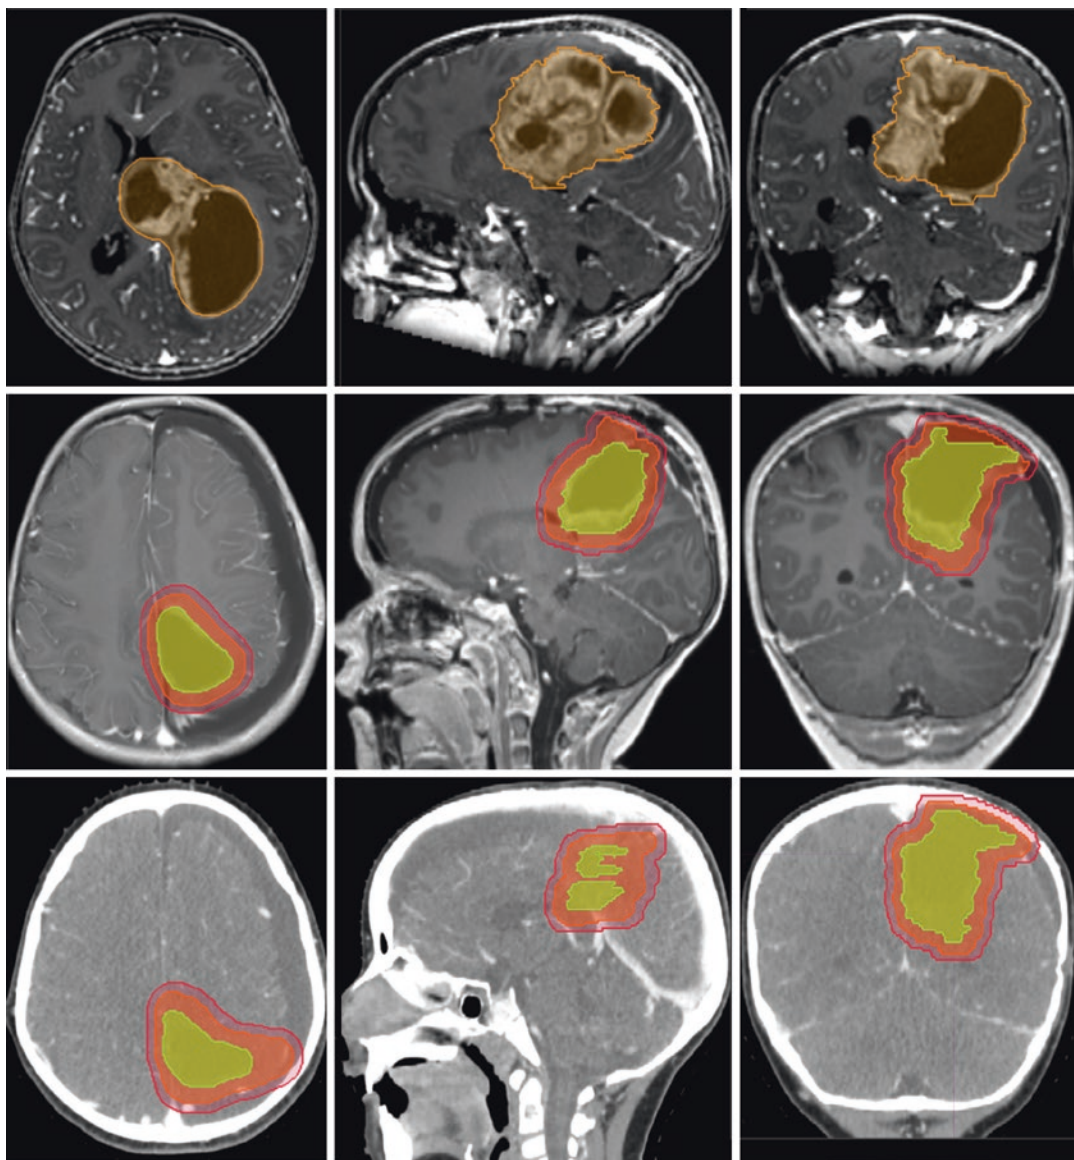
Supratentorial ependymoma pre-operative (upper row) MR images; post-operative (middle row) MR images showing gross-tumor volume (yellow), clinical
